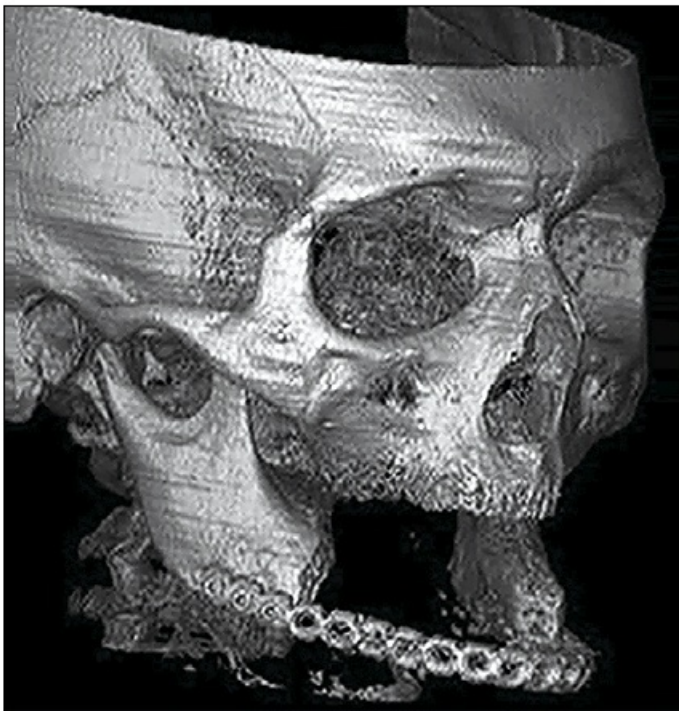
Three-dimensional CT scan of size defect (upper) and CAD plan of ideal mandibular transplant (lower)
